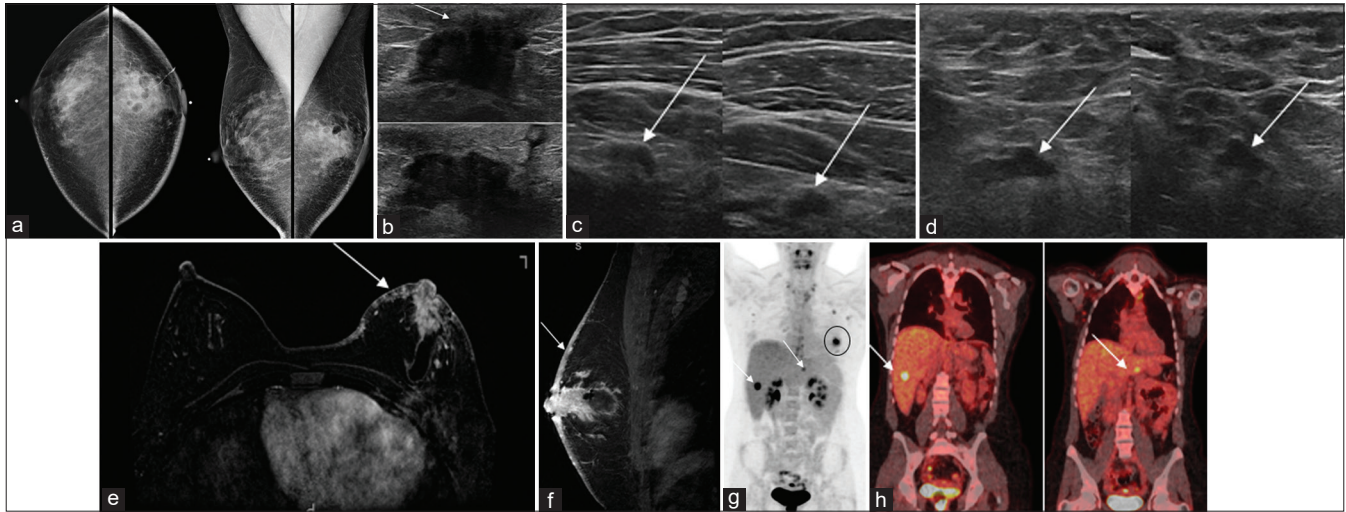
A 29-year-old woman 4 months postpartum noticed an inability to breast feed from the left breast. She later developed a palpable area in the left breast that did not resolve with warm compresses. One month later, she developed a rash and erythema that did not improve with antibiotics. Initial work-up was performed with surgical excisional biopsy with pathology yielding carcinoma. A referral to radiology and subsequent imaging workup was then performed, starting with a mammogram. (a) Craniocaudal (left) and mediolateral oblique (right) mammograms demonstrate post-excisional biopsy changes of the left breast, a focal asymmetry in the central region of the left breast, 3 cm from the nipple, associated global skin thickening (arrow) and trabecular thickening. (b) Longitudinal (top) and transverse (bottom) ultrasound images of the palpable area in the central region of the left breast demonstrate a hypochoic irregular mass, measuring $3.5 \times 2.5 \times 1.9$ cm, with extension to the nipple base (arrow). (c) Transverse (left) and longitudinal (right) ultrasound of the left regional nodal basin demonstrates multiple abnormal lymph nodes, including infraclavicular lymph nodes (arrows). (d) Transverse (left) and longitudinal (right) ultrasound of the right axilla demonstrated an abnormal lymph node with a cortical bulge (arrow). Ultrasound-guided core needle biopsy of the left breast mass revealed poorly differentiated invasive ductal carcinoma, which, in addition to the skin changes, was consistent with inflammatory breast cancer. Ultrasound-guided-fine-needle aspirations of abnormal lymph node in the left infraclavicular region and the right axillary region yielded metastatic carcinoma. (e) Axial T1-weighted contrast-enhanced MRI and (f) sagittal T1-weighted contrast enhanced MRI demonstrates an irregular heterogenous enhancing mass with an associated seroma that measures $4.1 \times 1.8 \times 2.2$ cm, in the central region of the left breast. There is direct extension of the malignancy to the nipple areolar complex. There is global skin thickening with heterogenous nodular enhancement of the dermis (arrow), consistent with dermal tumor emboli. These skin findings are key MRI features of inflammatory breast cancer. Coronal PET CT (g and h) demonstrate that in addition to the index left breast carcinoma (black circle) and bilateral lymphadenopathy, there were two liver masses which demonstrated increased FDG avidity (arrows). Ultrasound-guided core needle biopsy of the right liver mass demonstrated metastatic carcinoma.
